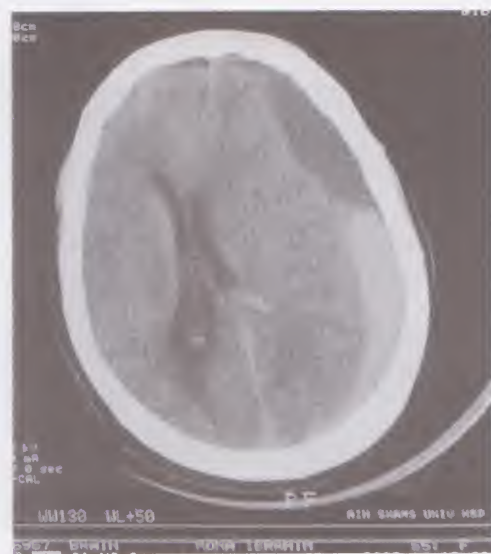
CT brain showing a left-sided subdural hematoma. The upper part appears hypodense (black) in comparison to normal brain; a chronic subdural hematoma. The lower part appears hyperdense (more white) denoting an acute subdural hematoma
